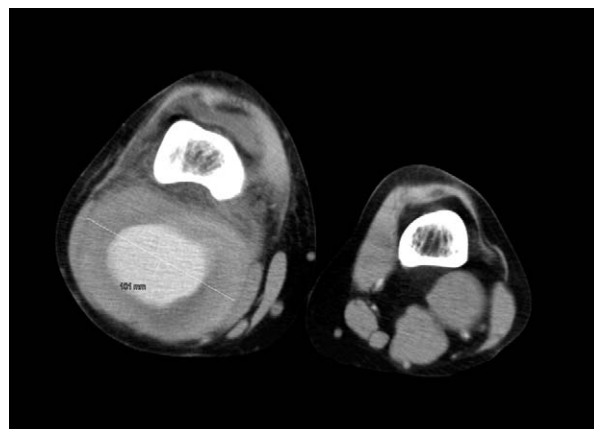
Computed tomography scan obtained during the initial evaluation, showing a large 10.1 × 8-cm right popliteal aneurysm with mural thrombus and a contralateral left popliteal aneurysm measuring 3.5 cm.
